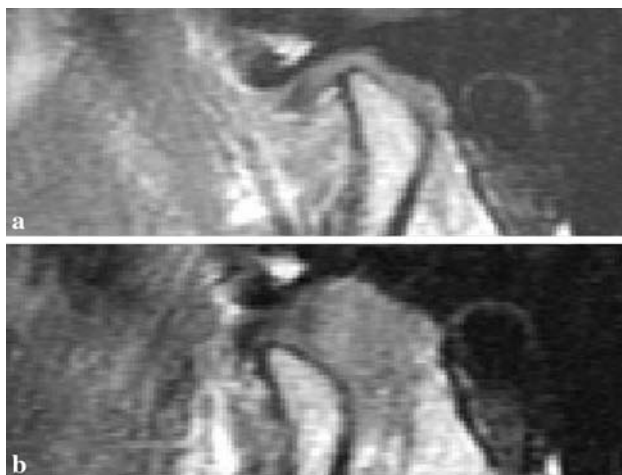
MRI of PADD: a closed and b open mouths
